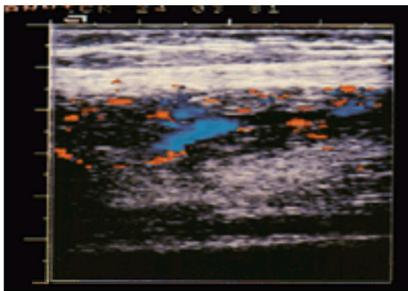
Deep venous haemangioma of the calf in a 13-year-old girl with leg pain. Colour Doppler demonstrates a hypervascular lesion.
